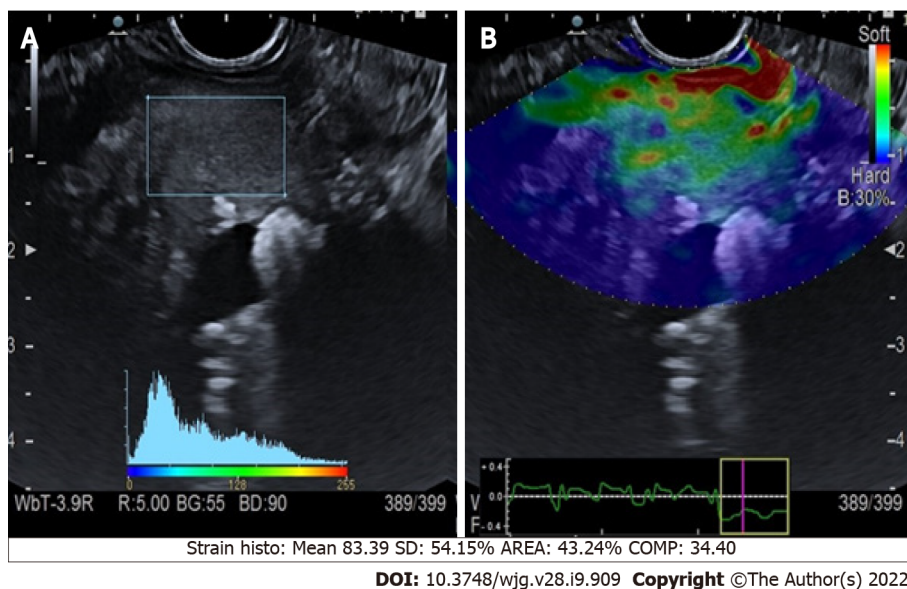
Quantitative endoscopic ultrasound elastography of chronic pancreatitis. A: Endoscopic ultrasound B-mode with region of interest square; B: Elastographic image.
